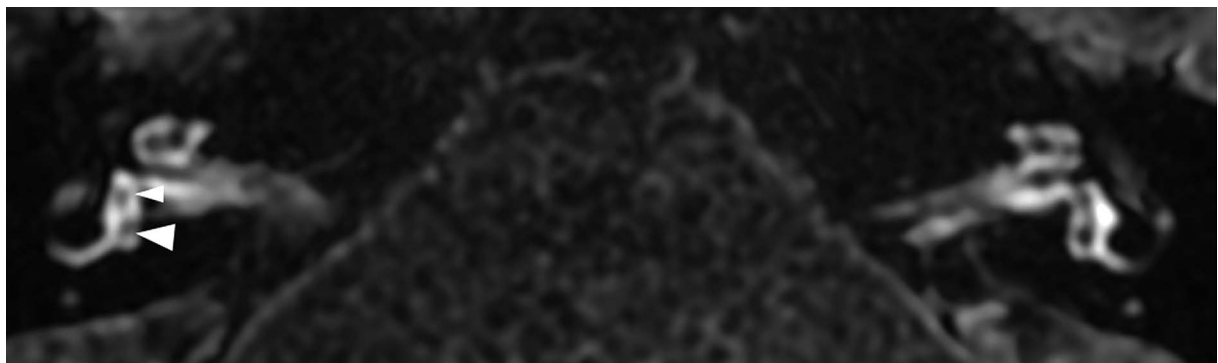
Magnetic resonance images of a 60-year-old female (patient #1) with right-sided clinically defined Ménière's disease. According to the Barath [11] and Bornaerts [13] classification, the example case of a normal vestibule classified as grade 0 vestibular hydrops. Delayed-postcontrast 3D-FLAIR T2 axial image of both ears below the level of modiolus (inferior part of the vestibule). The saccule (marked with a small arrowhead) and utricle (marked with an arrowhead) are well visualized. The saccule is smaller than the utricle, and endolymphatic structures encompass less than 50% of the vestibular area
